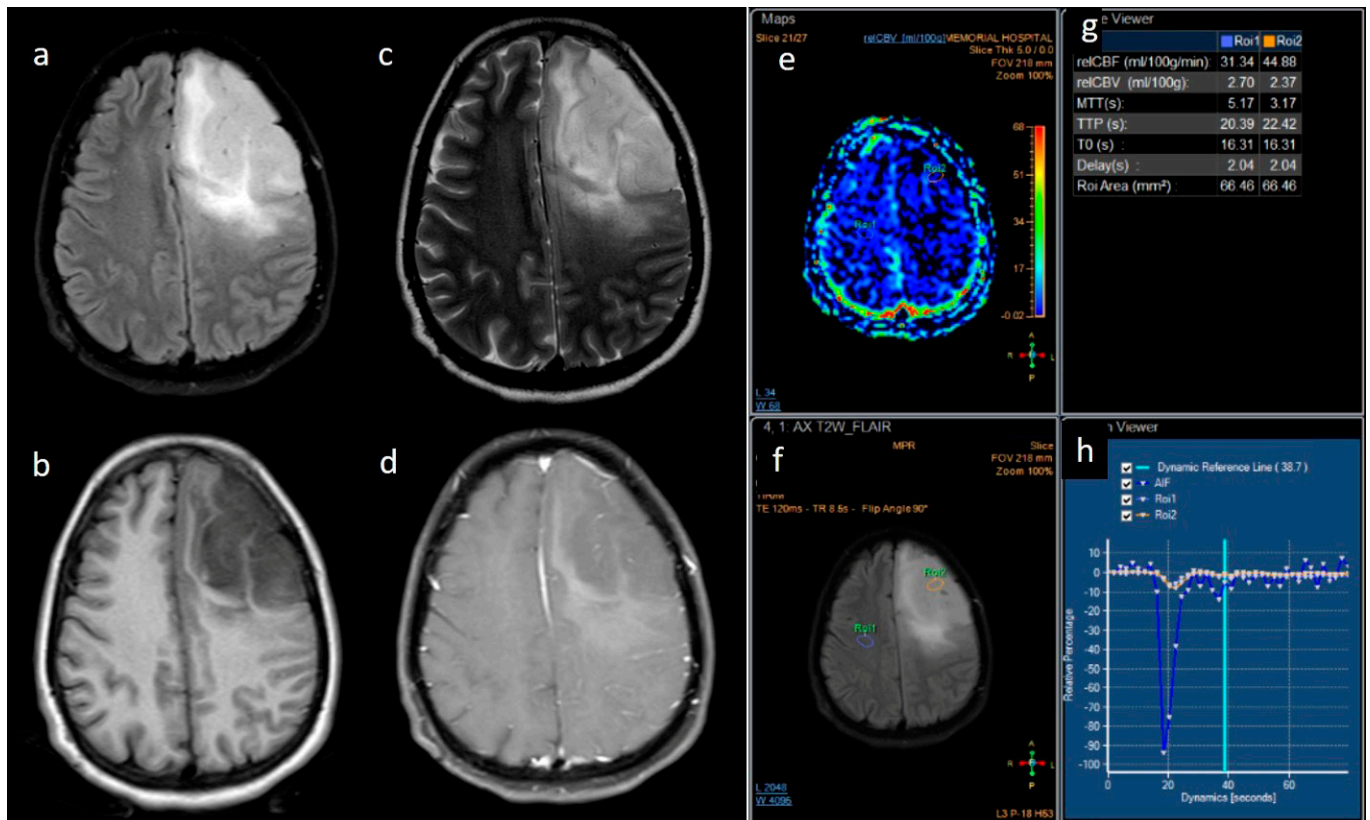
(a–h) FLAIR, T1, T2, post-contrast T1, perfusion color map, and graph representative of IDH-mutant grade 4 astrocytoma. Images a–d show a homogenous well-circumscribed mass without necrosis and edema less than the tumor volume. Images e–h are dynamic susceptibility contrast images showing hypoperfusion.
